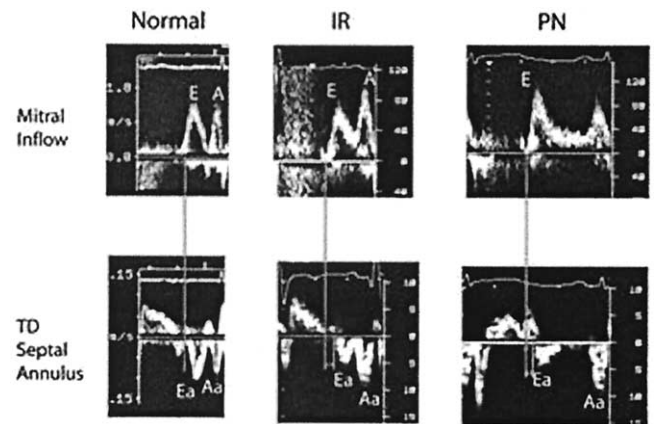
Mitral and tissue Doppler (TD) recordings of the mitral annulus from a normal, an impaired relaxation (IR), and pseudonormal (PN) patients. Notice the later onset of Ea with respect to onset of mitral E in the IR and PN patients.
